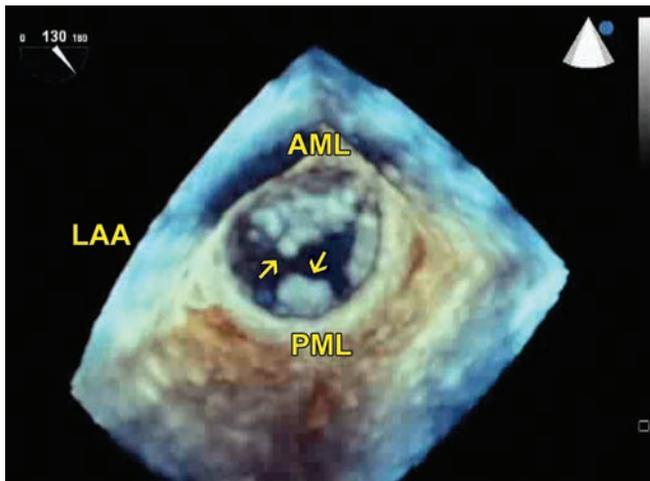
Transesophageal 3D imaging of the mitral valve. Notice the masses attached to the mitral valve, at P2 and A2 scallops (arrows).
